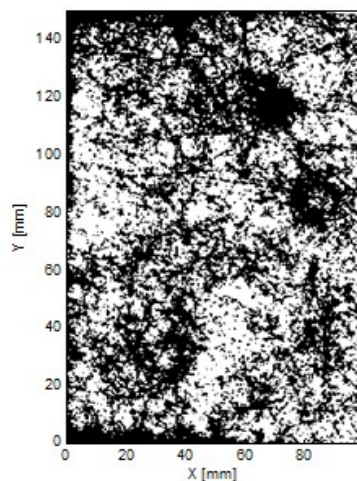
The binary image of the X-ray radiography
